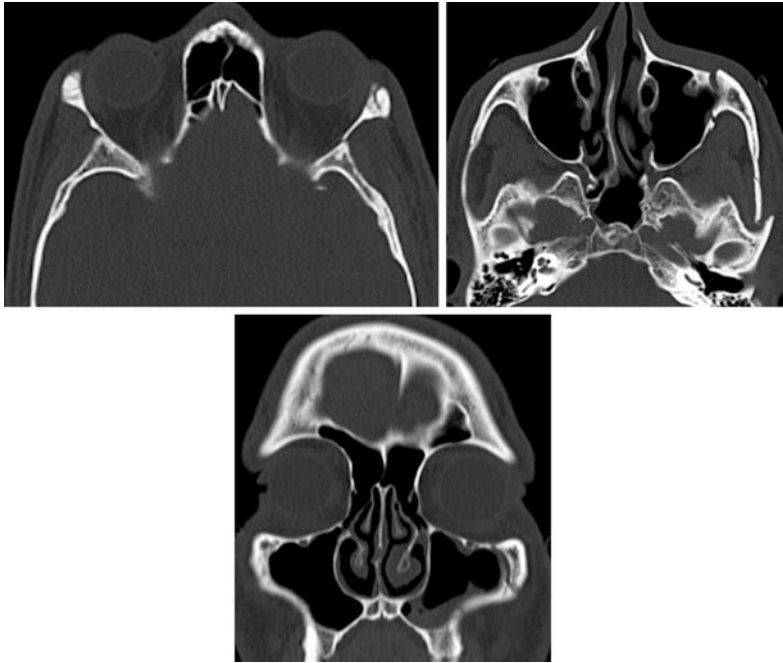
Zygomaticomaxillary complex fracture. a, b Axial and c Coronal reformatted CT images demonstrate fracture of the lateral and inferior orbital wall and left zygoma, without angulation of the lateral orbital wall or changes in orbital volume
